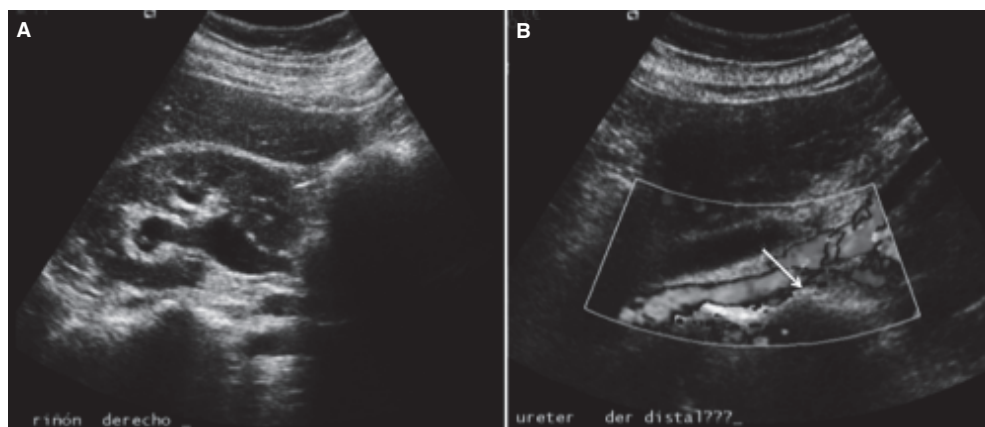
Abdominal ultrasound dedicated to kidneys shows: A. Pyelocaliceal dilatation in an oblique plane through right kidney. B. Tubular structure along the way of the right ureter without flux demonstration with Doppler modality, which probably represents dilation of right ureter.
